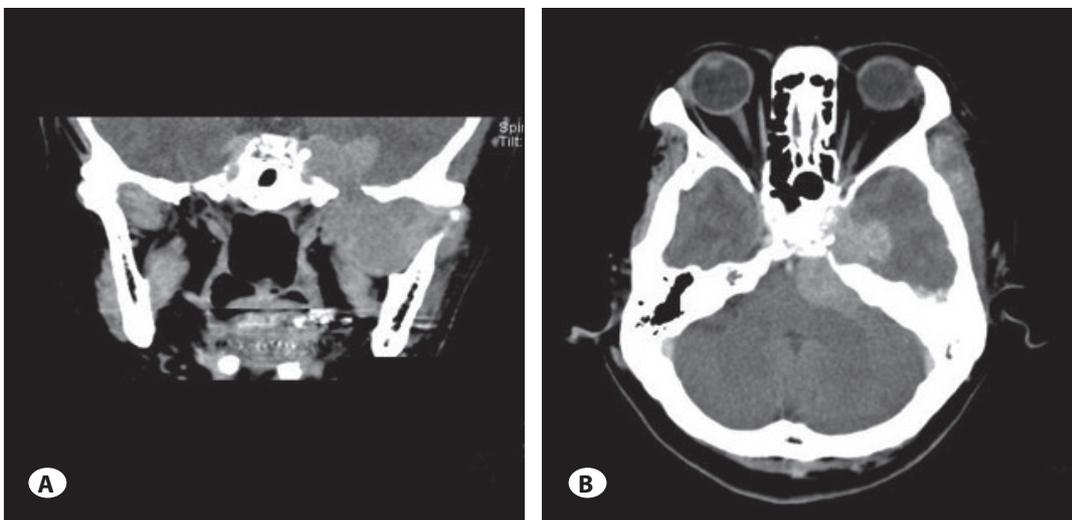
Post-contrast brain CT showed a extra-axial dumbbell-shaped tumor across foramen ovale. Notice the left foramen ovale was much larger than the right side due to tumor erosion (A). The tumor extended to posterior fossa with compression of brain stem. Erosion of anterior portion of petrous bone was shown (B).
